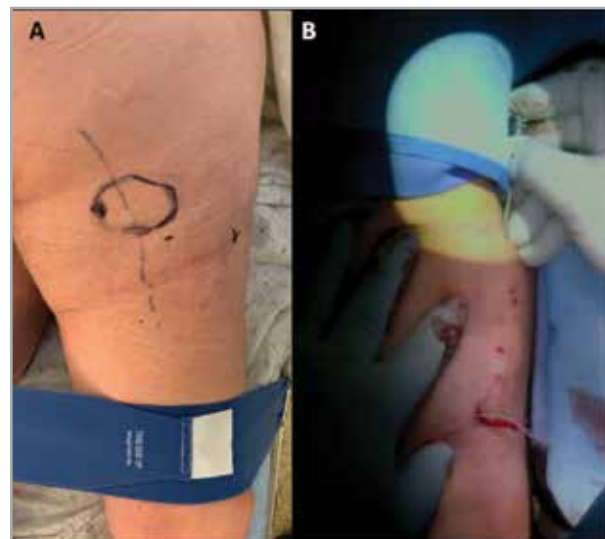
2A: Ultrasound was utilized to localize the sciatic nerve (circled) and an entry point was approximated 8 cm laterally (dot). 2B: After the appropriate lead placement, the distal portion was tunneled superiorly and laterally.
